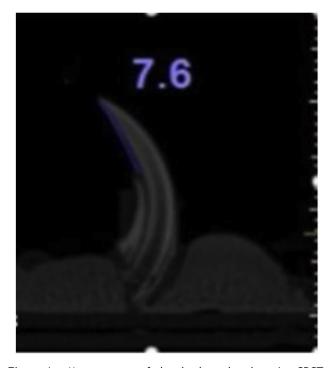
Measurement of alveolar bone loss by using CBCT, measurements being made along the axis of the crown in the midlingual side.
